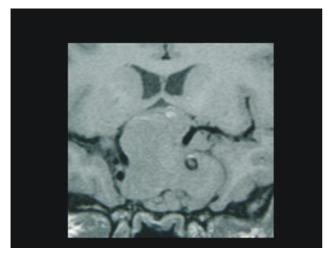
Post-contrast T1-weighted sagittal MR image and B. coronal MR image showing the massive vertical extent of a giant pituitary adenoma (Grade I) obliterating the third ventricle and reaching upto the corpus callosum. There is no cavernous sinus invasion.
